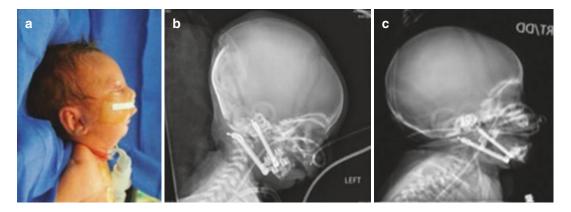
(a-c): Preoperative and postoperative photographs and radiographs of a patient undergoing mandibular distraction osteogenesis through a submandibular approach
